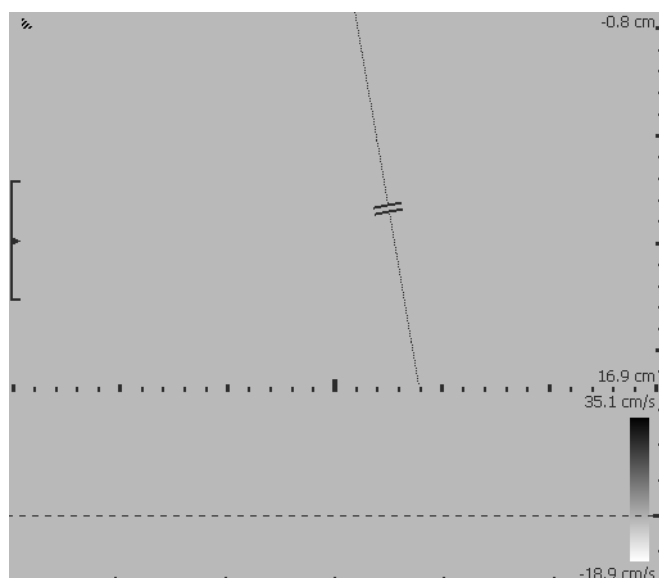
The Doppler indicator (line and gate) superimposed on a B-mode image.
